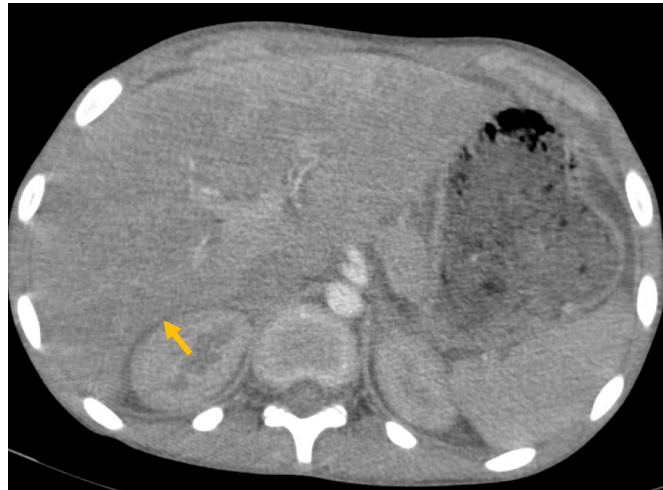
Axial contrast-enhanced abdominal CT showing thrombosis of the right portal vein (arrow), consistent with pylephlebitis
